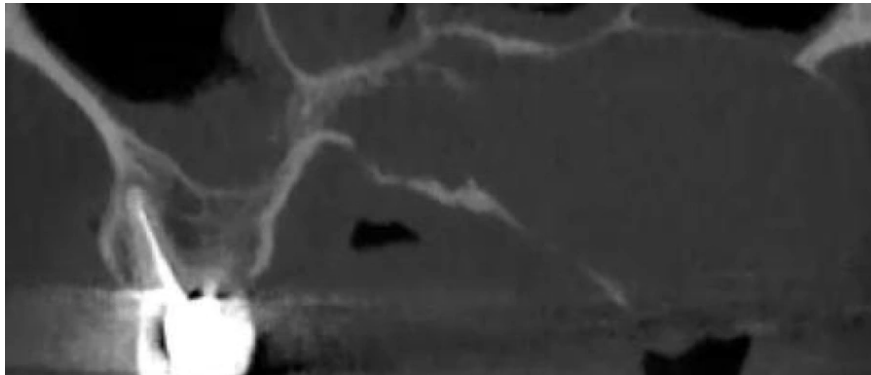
Radiographic image demonstrating a thin wispy internal septum within the maxillary lesion, a characteristic internal radiographic feature of the lesion.
